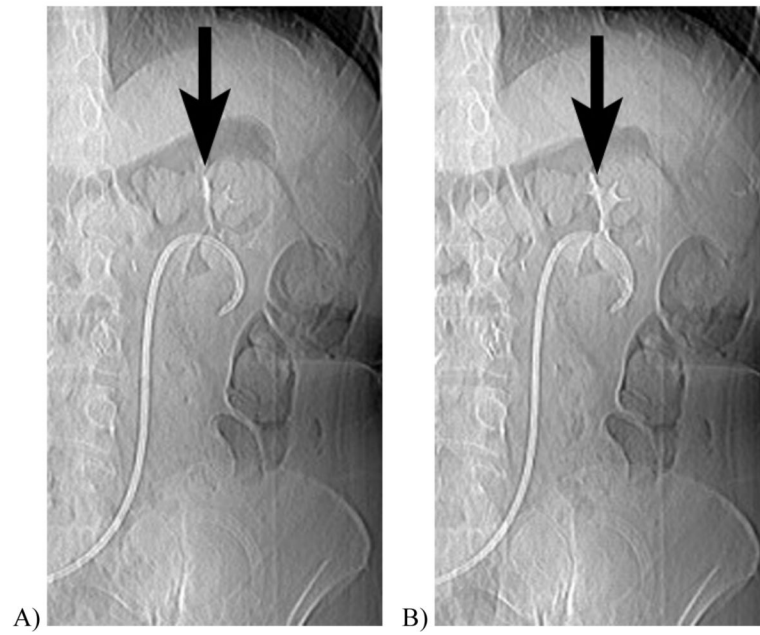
CT scout obtained 10 minutes after intravenous contrast injection in a 61 year-old woman with cystectomy and ureteral stents. When imaged at A, 120 kVp, the excreted iodinated contrast material is barely visible in the renal calyces, but at B, 80 kVp the enhanced calyces are readily seen.
